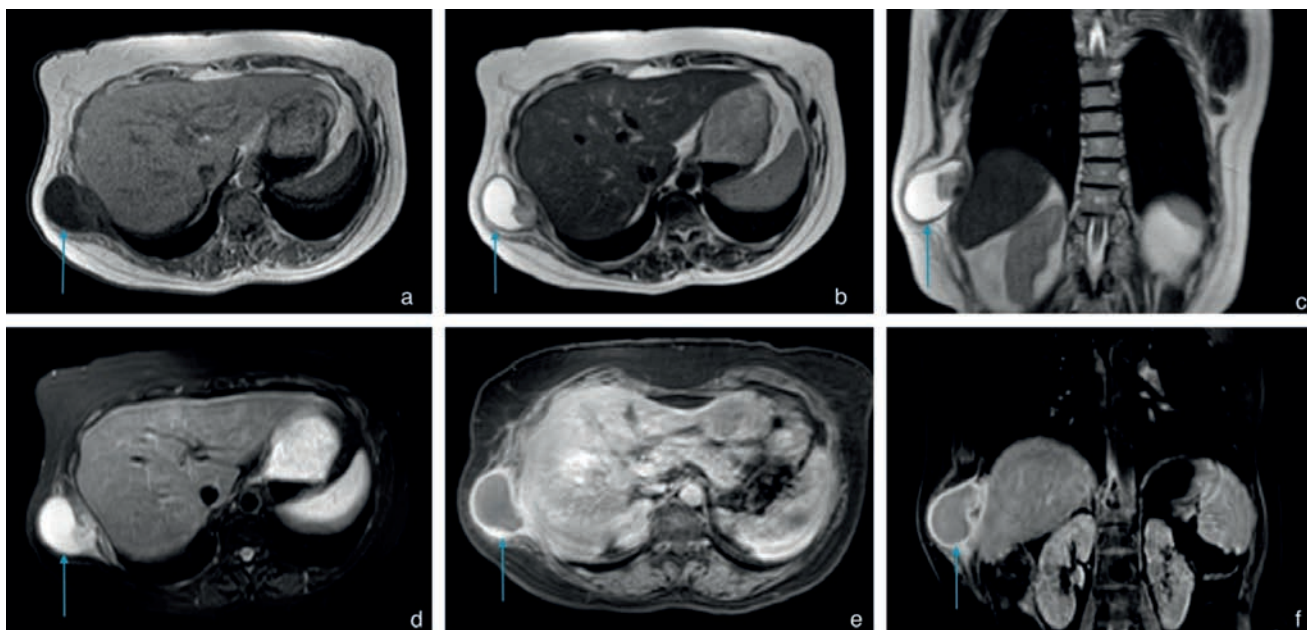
Chest MRI shows extra-thoracic, T1 - focal hypointense and T2 - focal hyperintense uni-loculated collection at right lower lateral chest wall in lateral shaft of right 9th rib (SPAIR - hyperintense, DWI - no reduced diffusivity, ADC - $1.9 \times 10^{-3} \text{ mm}^2/\text{s}$, GRE - no blooming, C+ T1 - non-enhancing), eccentric heterogenous suspicious soft tissue component (? calcification) of size $\sim 18 \times 24 \times 33 \text{ mm}$ with irregular margins (SPAIR - heterogenous hypo-hyperintense, DWI - reduced diffusivity, ADC - $0.6 \times 10^{-3} \text{ mm}^2/\text{s}$, GRE - few blooming areas (? calcifications), C+ T1 - mild heterogenous enhancing, peripheral mild enhancing hypointense smooth thin margin of the collection. Collection extending medially involving extra-pleural fat, serratus anterior muscle and causing bony erosion of lateral shaft of right 9th rib, laterally abutting right latissimus dorsi muscle associated with sub-cutaneous minimal edema
